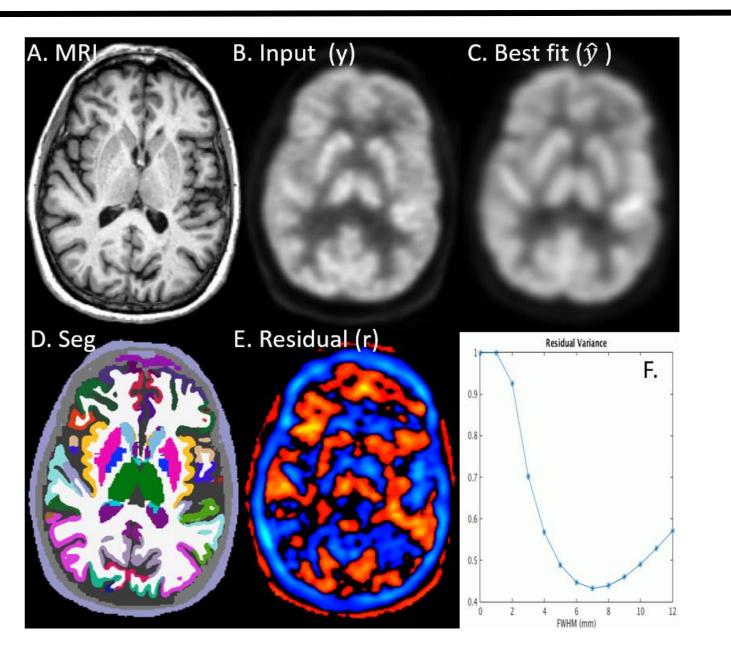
GTM on real data. (A) Anatomical MRI. (B) Input PET image (y, 18F-FDG, HABS). (C) Best fit image (eq. 3), (D) Segmentation of MRI into the ROIs used for the GTM. (E) Map of residual error (eq 4). (F) Plot of residual variance (eq. 5) against PSF FWHM; there is a clear minimum at about 7mm FWHM. AGTM finds this minimum.
